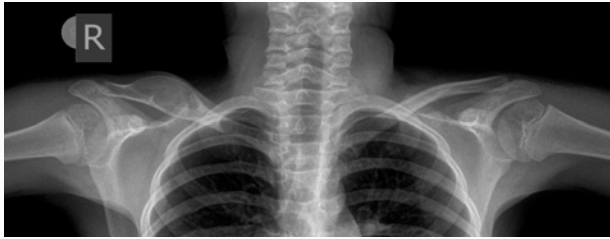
X-ray examination shows expansile lytic lesion in the right clavicle.
